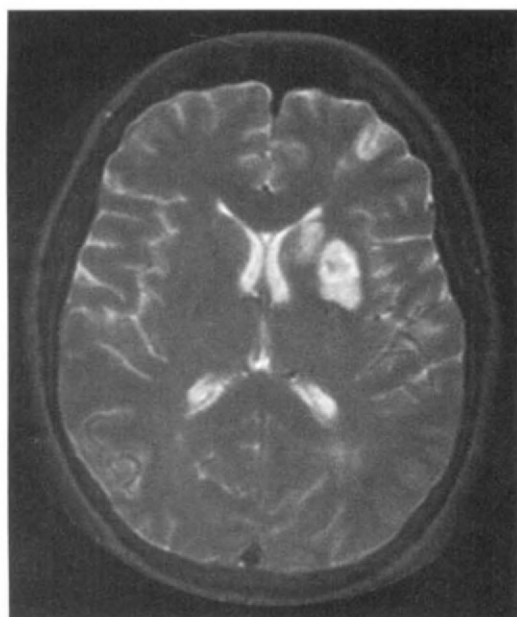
Magnetic resonance image of the brain demonstrates abnormally increased T₂ signal involving the left caudate nucleus and basal ganglia.
